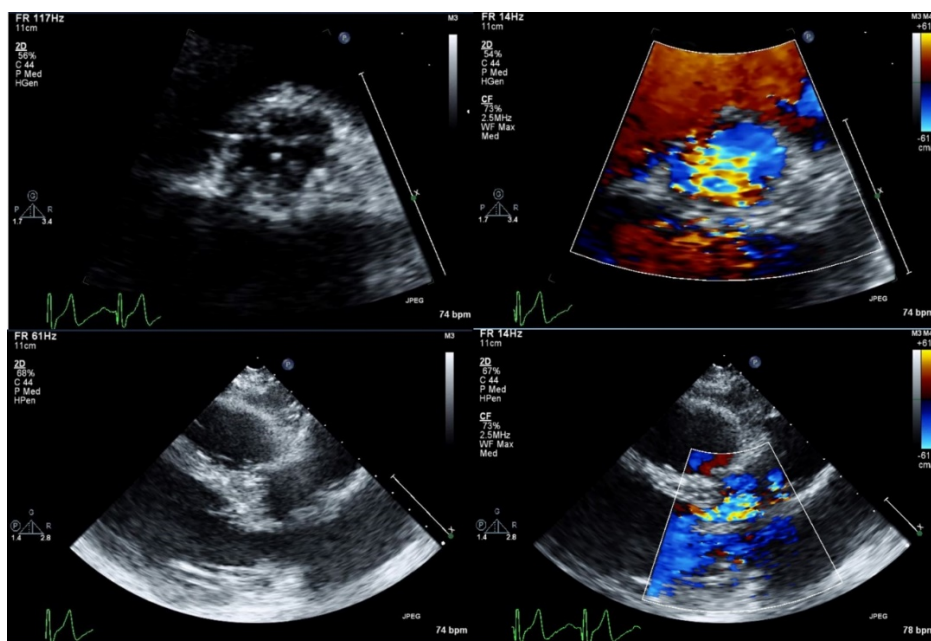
Transthoracic echocardiographic images obtained pre-TAVR. Top Left: Parasternal short axis. Top Right: Parasternal short axis with color showing AR. Bottom Left: Parasternal long axis. Bottom Right: Parasternal long axis with color showing AR.
